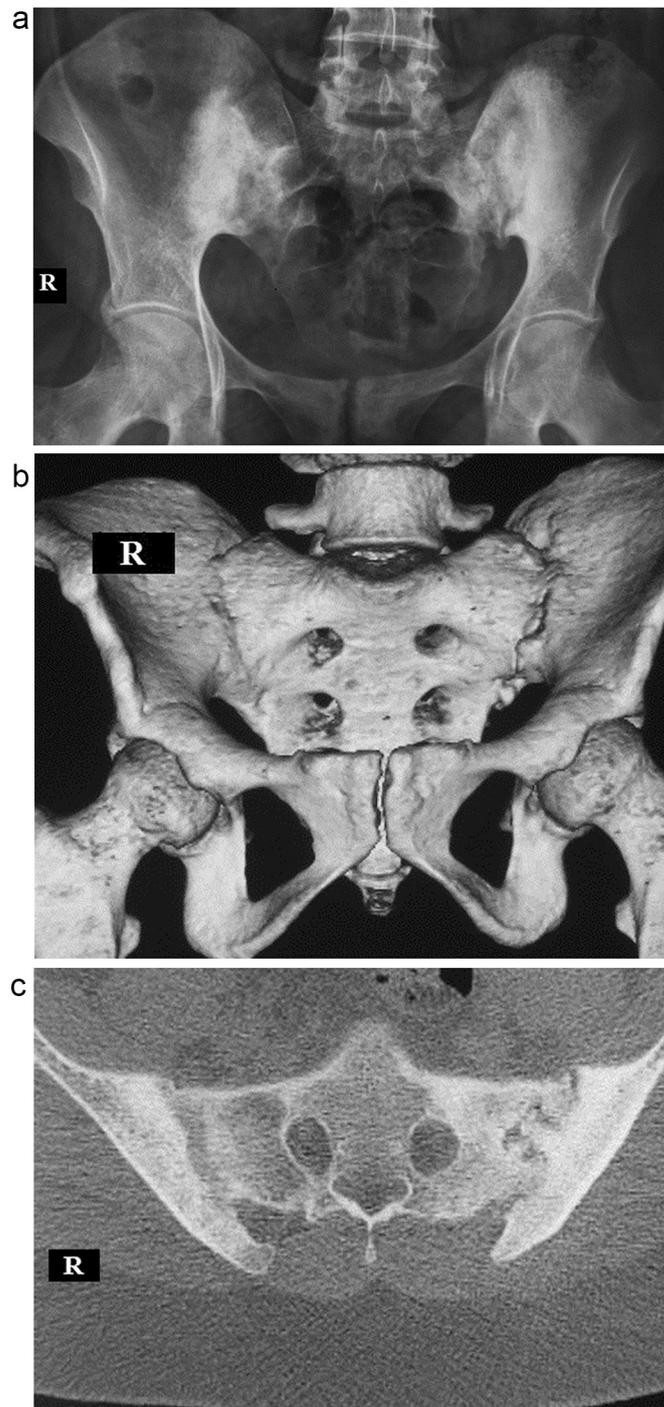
(A) Plain Radiograph AP view, (B) reconstructed CT pelvis, (C) axial CT scan at 18th month of follow-up. Showing sclerosis around both SI joint region and complete ankyloses of the joint on the right side and incomplete on the left side.
